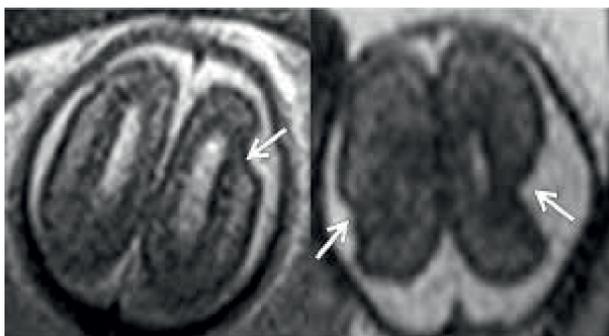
MRI changes in the brain of the surviving twin after the death of co twin. Courtesy-(pubs.rsna.org).
